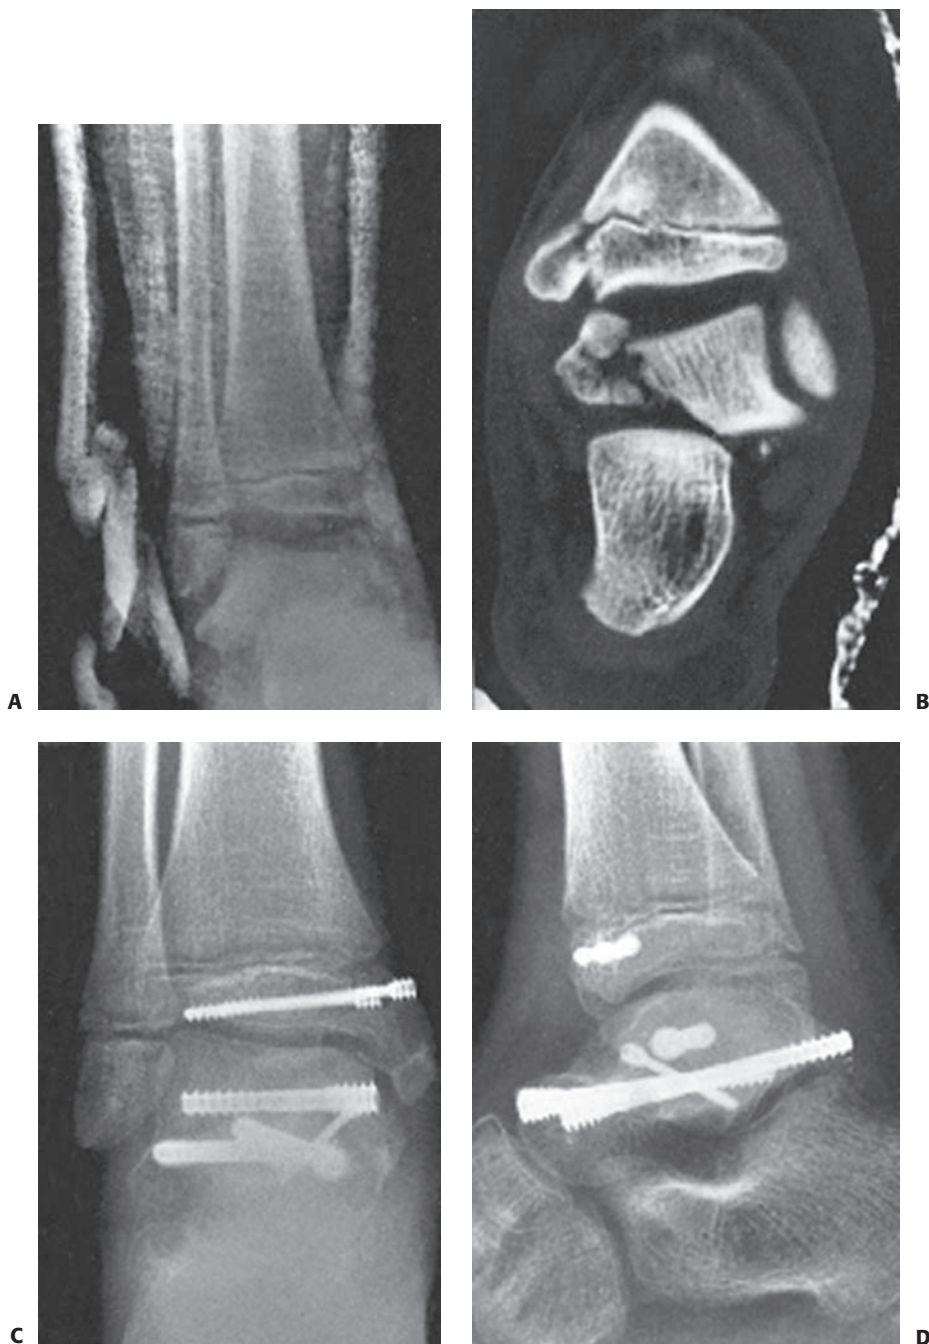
A: Severe ankle injury sustained by an 8-year-old involved in a car accident. The anteroposterior view in the splint does not clearly show the Salter–Harris type IV fracture of the tibia. The dome of the talus appears abnormal. B: CT scan shows the displaced Salter–Harris type IV fracture of the medial malleolus and a severe displaced intra-articular fracture of the body of the talus. C, D: Open reduction of both fractures was performed, and Herbert screws were used for internal fixation. (Courtesy of Armen Kelikian, MD.)
